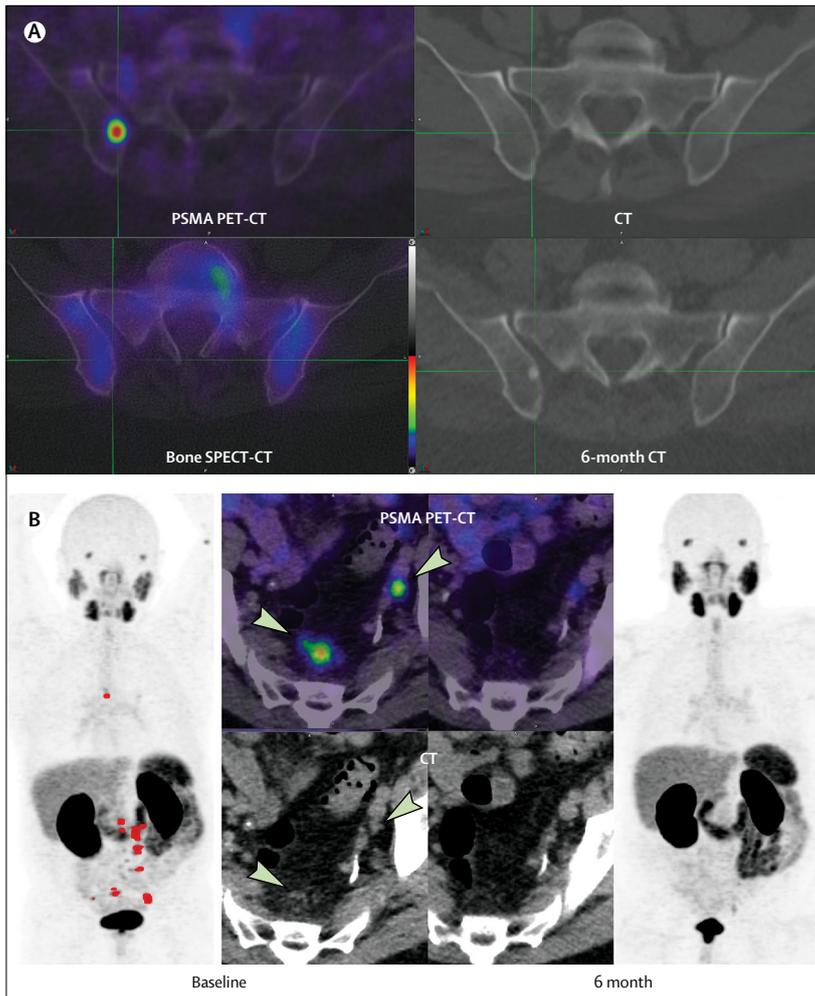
Images of two men with normal results from baseline conventional imaging (A) PSMA PET-CT showed a right iliac bone metastasis in the first patient and 6-month follow-up imaging following systemic treatment showed regression of PSMA PET-CT findings with progressive sclerosis on CT. (B) PSMA PET-CT showed multiple sub-cm pelvic and distant nodal metastases in the second patient and 6-month follow-up imaging following systemic treatment showed regression of PSMA PET-CT findings with a decrease in the size of nodal changes on CT. Furthermore, prostate-specific antigen was undetectable in both patients at 6 months' follow-up. PSMA=prostate-specific membrane antigen.
